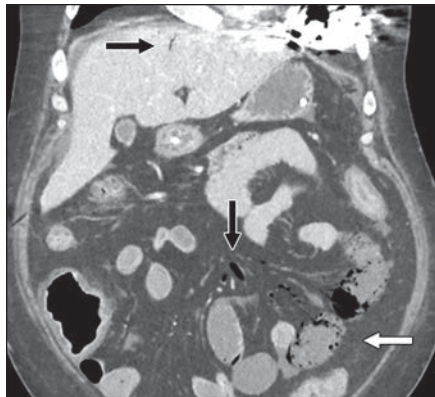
59-year-old patient with acute nonocclusive mesenteric ischemia after repair of abdominal aortic aneurysm and placement of left ventricular assist device. Coronal CT image shows jejunal pneumatosis (white arrow) and portomesenteric venous gas (black arrows).
